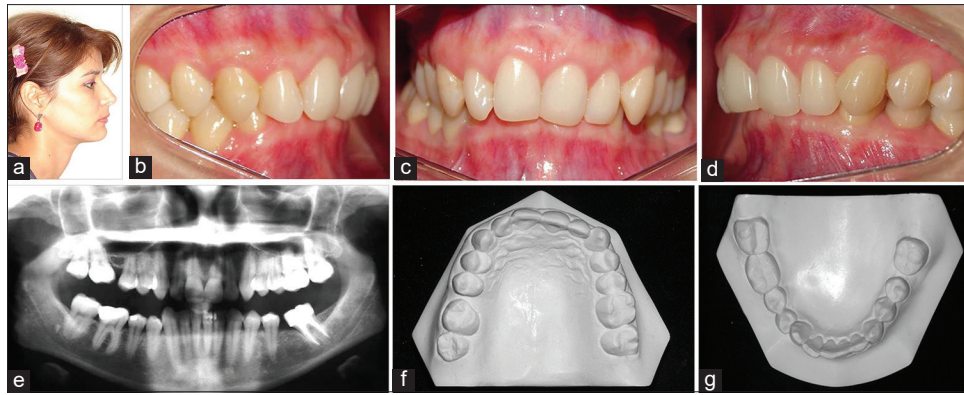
Pretreatment facial, intraoral and dental casts photographs, and panoramic radiographs (a-c) Class II, division 2 profile and malocclusion, (d-g) Loss of maxillary right first permanent molar and mandibular left first molar followed by mesial inclination of maxillary right second molar
